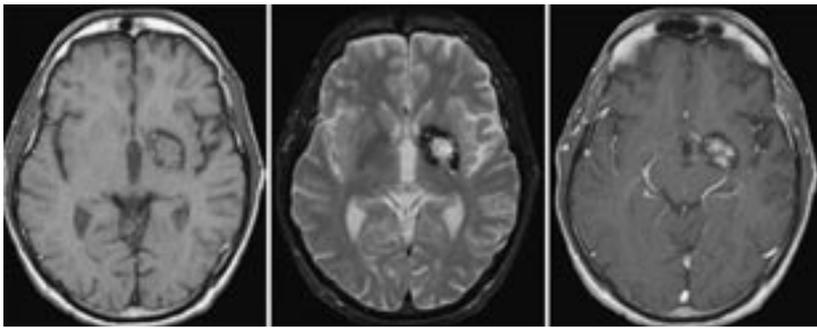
MRI scans of the brain, including T1-weighted (left), T2-weighted (center), and contrast-enhanced (gadolinium) T1-weighted (right) images, reveal the typical CM appearance in the left basal ganglia. The imaging reveals a mixed density lobulated lesion reflecting the lesion behavior. The low T2 signal reflects hemosiderin, and the hyperintensity reflects acute and subacute blood.
